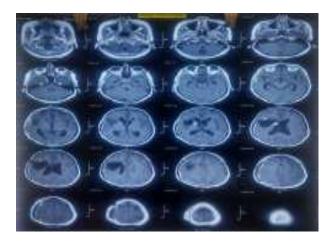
Postoperative CT scan Brain
